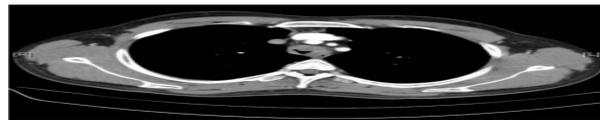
CT Thorax at the level of thoracic inlet showing luminal narrowing of the trachea
